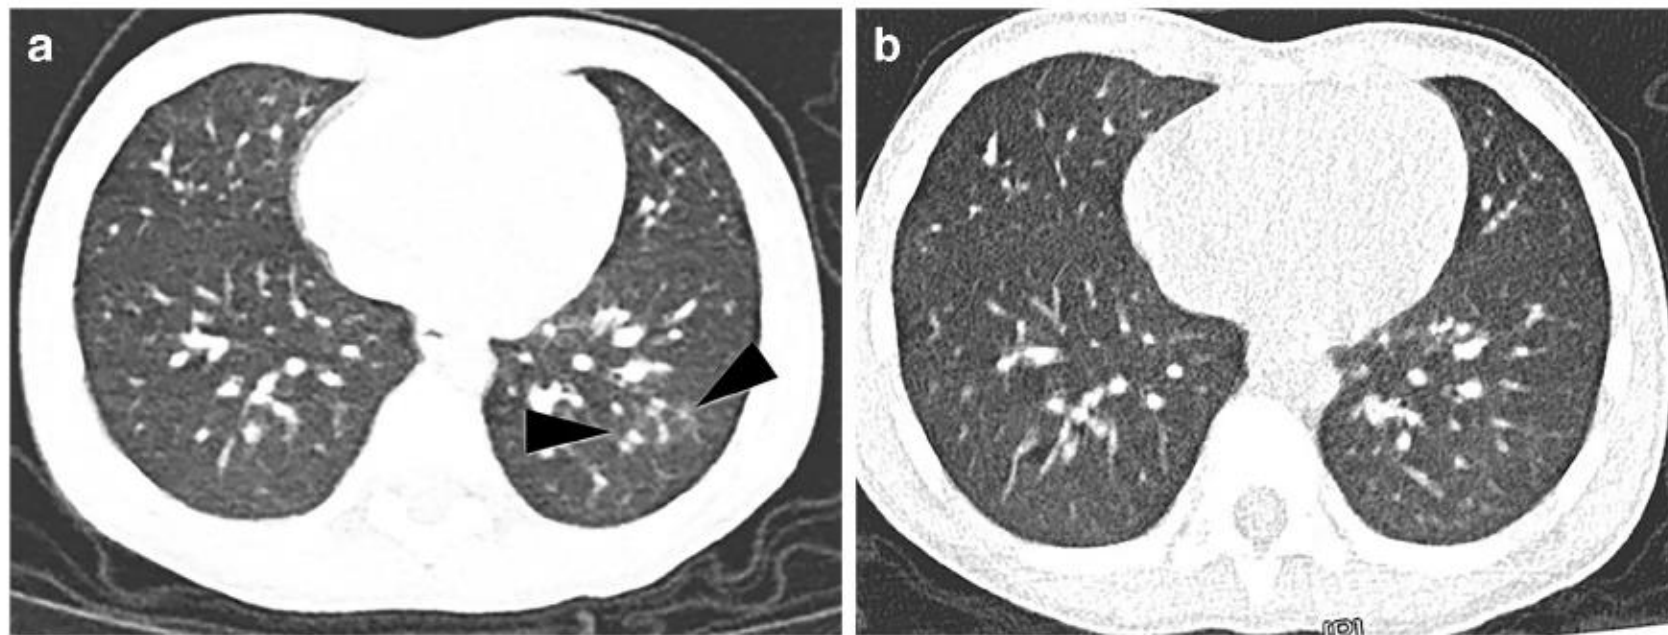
Axial non-enhanced chest CT in a 4-year-old boy (Patient 4 in Table 1). a Two days after admission there is patchy ground-glass opacification (*arrowheads*) of the left lower lobe. b Five days subsequently, during symptomatic and supportive treatment, the appearances have normalised
